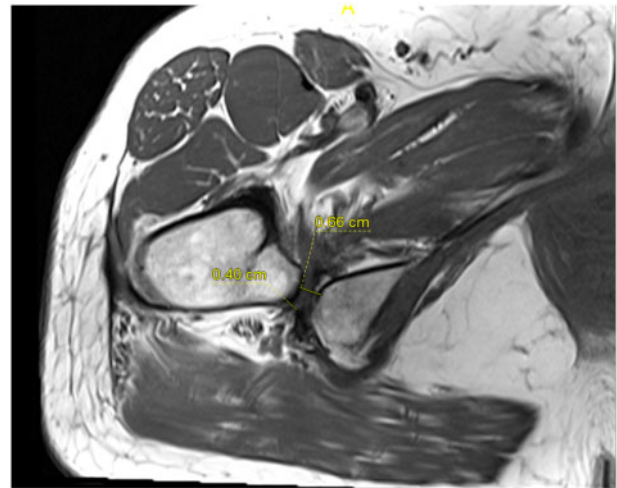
IFS: 0.66 cm and QFS: 0.40 cm on hip MRI T1 axial series.
